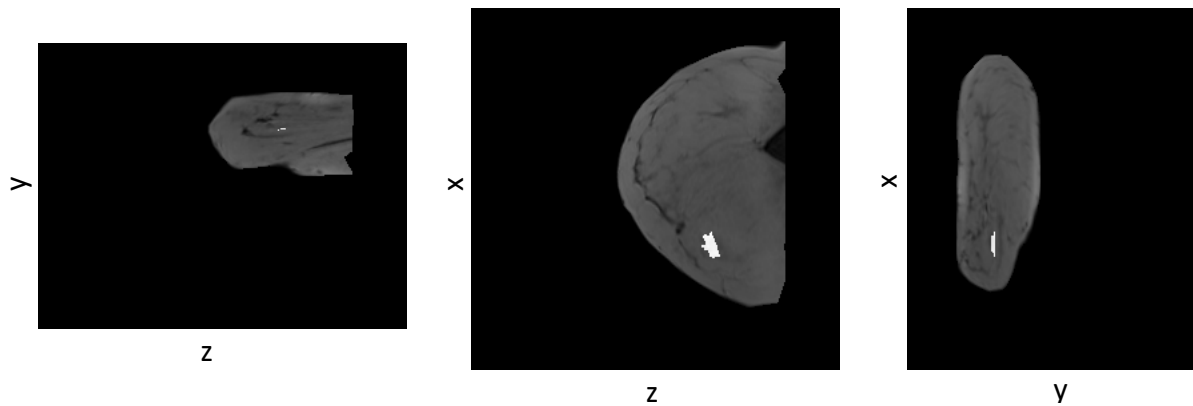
The exemplary case shows the tracked annotated lesion by the radiologist in three views of an MR image after applying the compression deformation to the breast.
